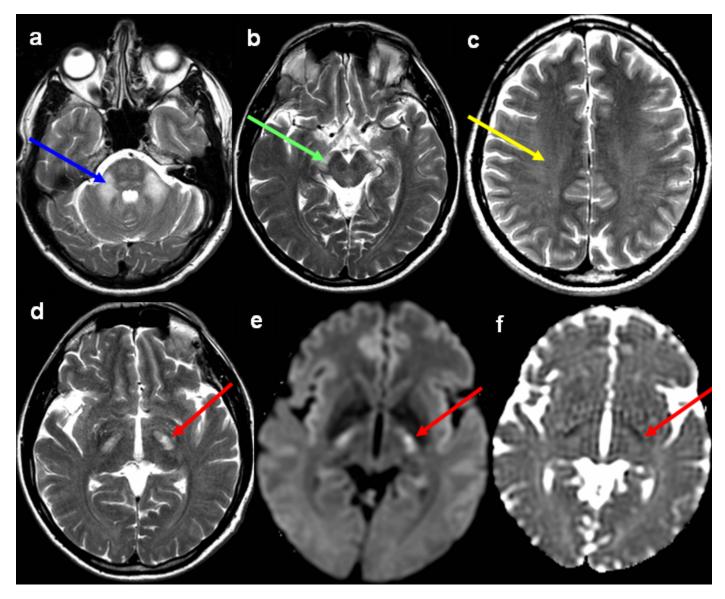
MRI of an individual age 50 years with *CLCN2*-related leukoencephalopathy. Note the T_2 -weighted signal abnormalities (a-d) in the middle cerebellar peduncles (blue arrow in a), crura cerebri (green arrow in b), and posterior limb of the internal capsule (red arrow in d). All cerebral white matter except for the directly subcortical white matter has a slightly abnormal signal (yellow arrow in c). The diffusion-weighted image (e) and apparent diffusion coefficient map (f) show diffusion restriction in the posterior limb of the internal capsule (red arrows).
